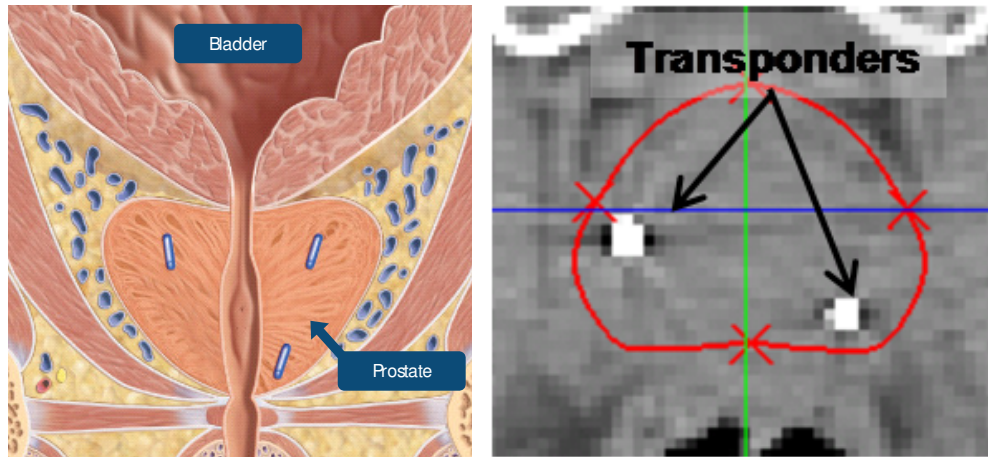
A typical setting of the Calypso system. Left: three transponders are implanted into the prostate to provide localization; courtesy of Calypso. Right: a CT image slice showing the prostate and two of the transponders.
